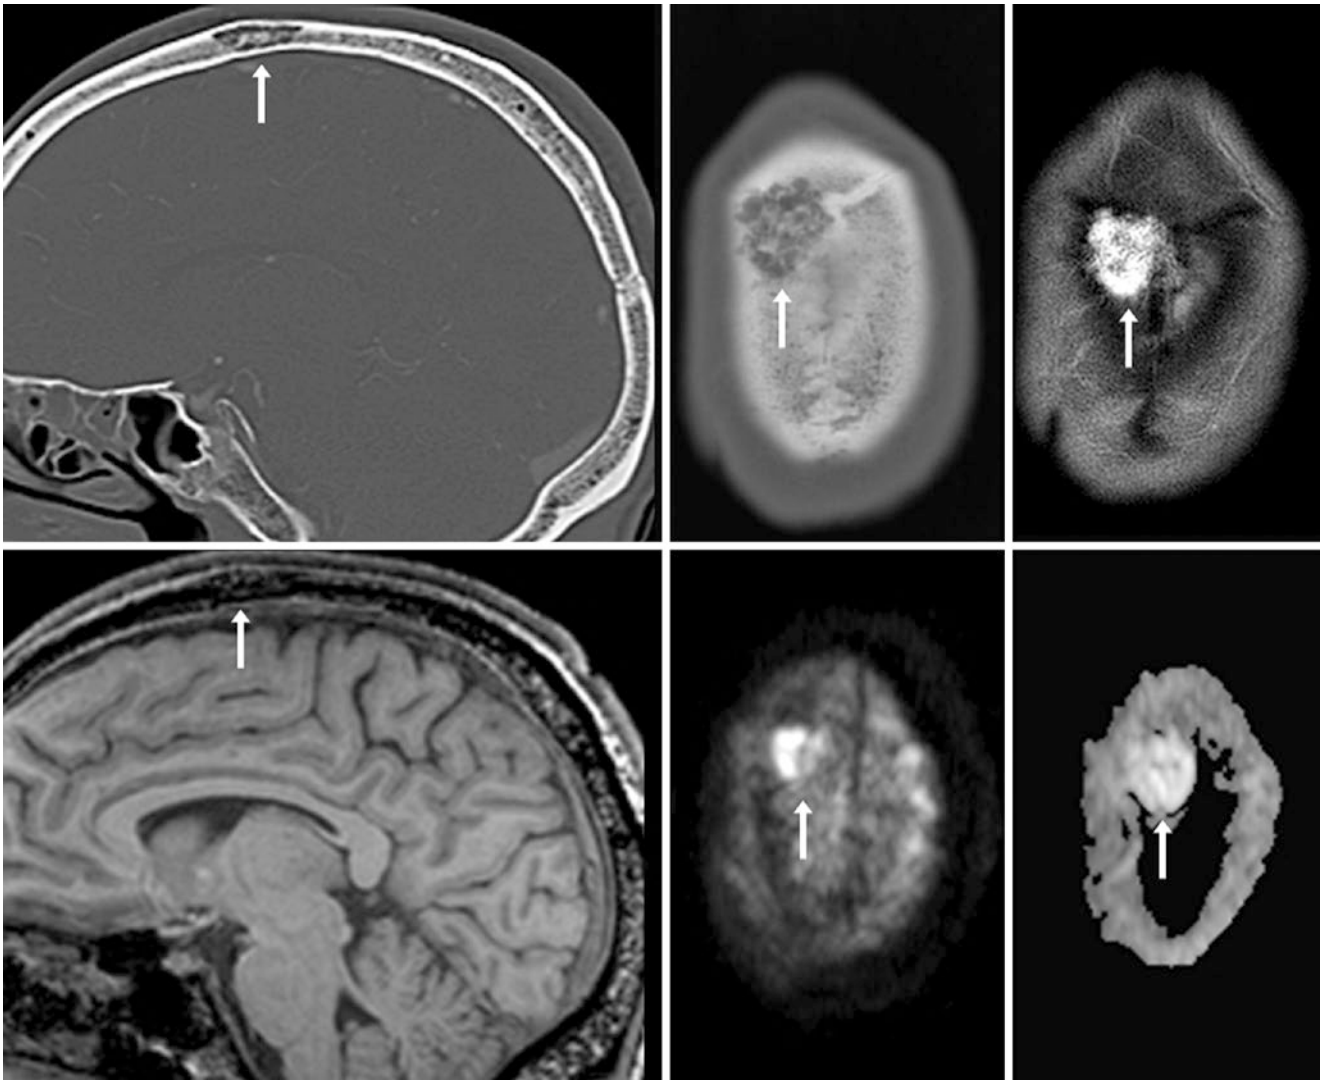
A 42 year old with a frontal bone lesion (*arrows*) that was noted on sagittal (*top left*) and axial (*top middle*) NECT. On a 1.5 T MRI, fat-suppressed T2WI (*top right*) depicted that it was heterogeneous but mostly bright, being relatively dark on sagittal T1WI (*bottom*
